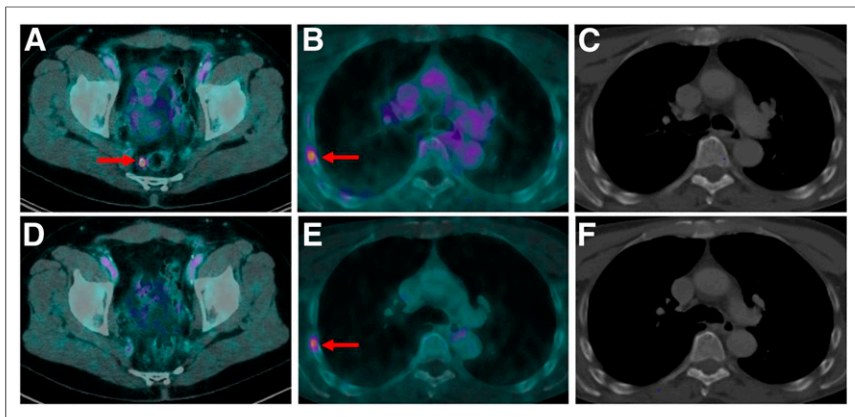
(A–C) Baseline ^{18}F -PSMA-1007 PET/CT of 65-y-old patient with BCR PC after RPE presenting with PSA value of 1.4 ng/mL. Images show single PSMA-positive LN metastasis para-rectally (A, arrow). (D) This LN was removed during PSMA radioguided surgery, with subsequent PSA decline to <0.2 ng/mL and follow-up ^{18}F -PSMA-1007 PET/CT showing no PSMA ligand uptake anymore. In this patient, unspecific focal PSMA ligand uptake in right fourth rib was observed (B, arrow; SUV_{max} , 4.4) and was still present on follow-up PET/CT (E, SUV_{max} , 4.6), with no morphologic correlate on corresponding CT images (C and F).
